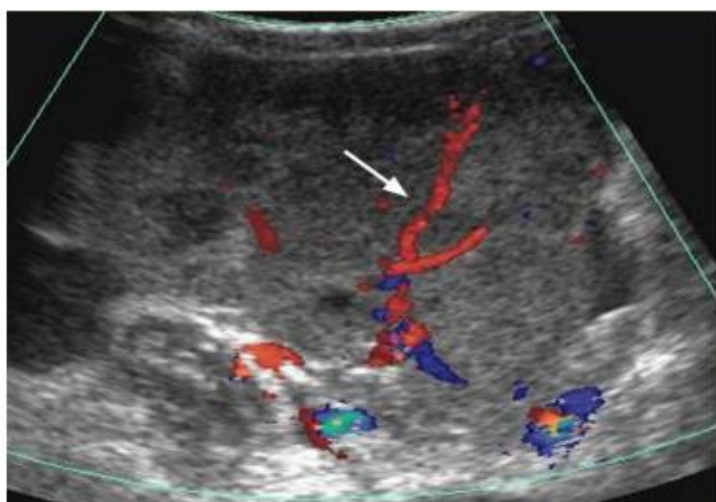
Dysgerminoma: Transabdominal Doppler US shows a lobulated hypoechoic solid mass with prominent blood flow in the fibrovascular septa (arrow) (7).
